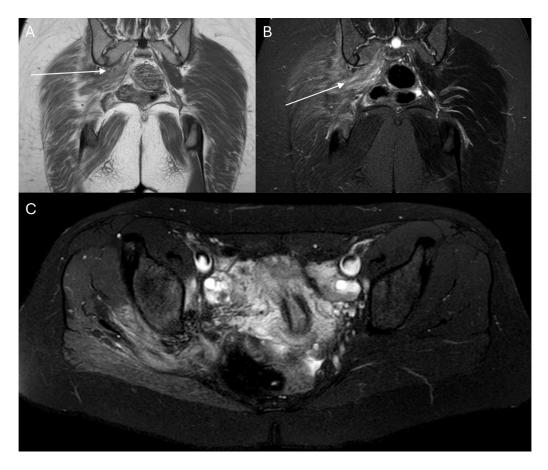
Initial MRI: T1 Coronal image demonstrates the presence of an ill-defined isointense enhancing signal involving the right sciatic notch (A). STIR coronal image displays well-defined hyperintense signal within the same region (B). T2-FS axial image demonstrates hyperintense soft tissue inflammatory changes at the level of the right sciatic notch, with hypointense foci thought to represent hemosiderin deposition (C).
